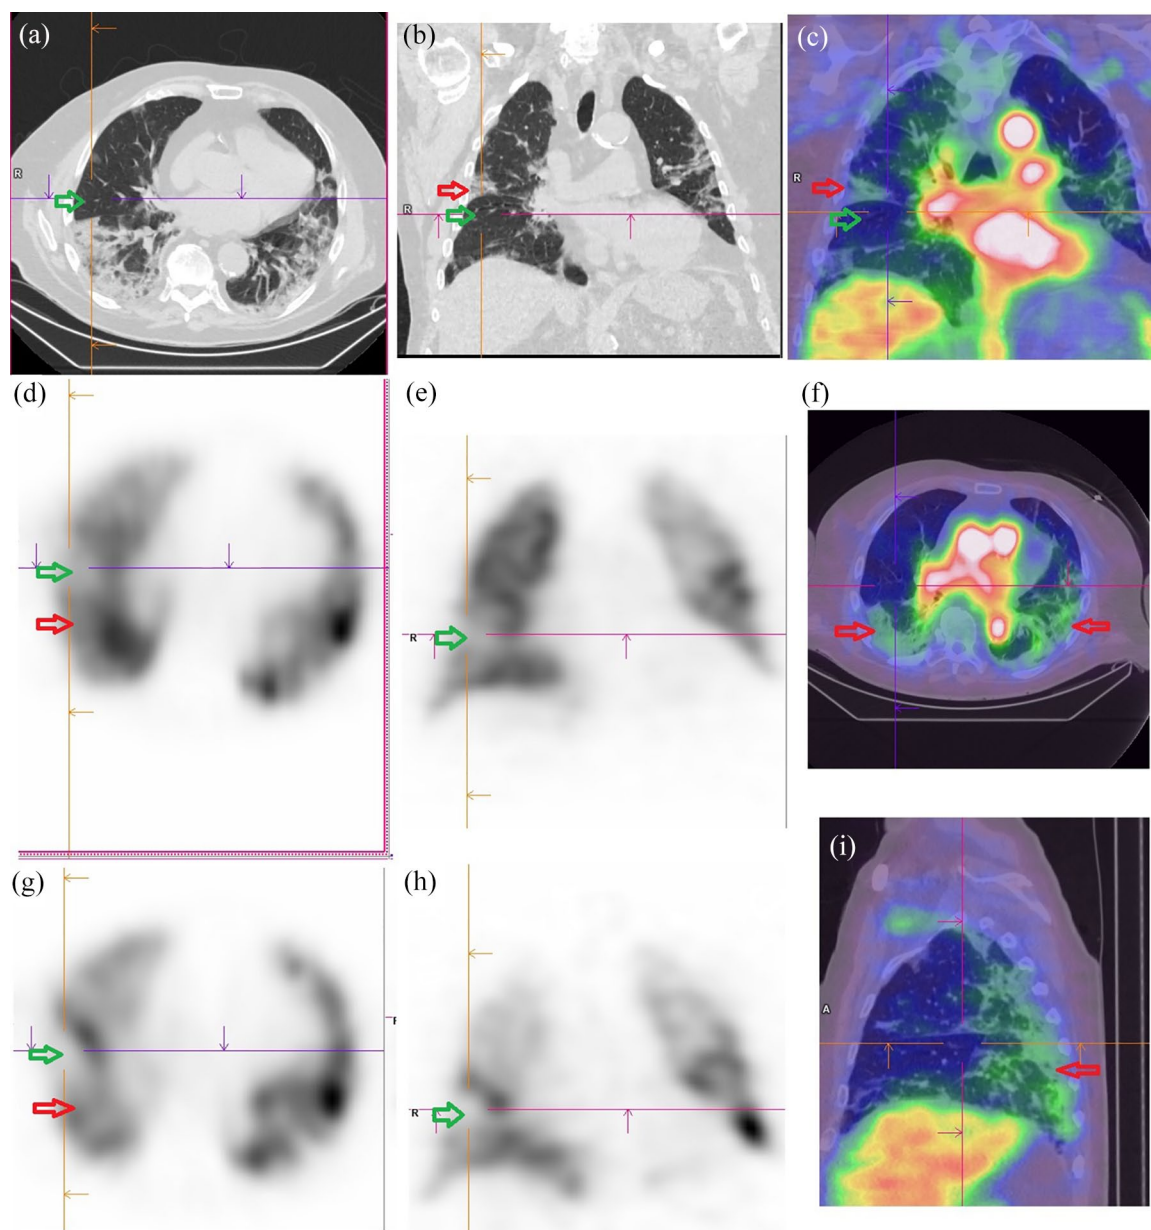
Patient no. 7. Axial (a) and coronal CT slices (b). Corresponding perfusion (d, e) and ventilation (g, h) scans. Corresponding coronal (c), axial (f), and sagittal (i) fused albumin and CT scans. Green arrow: non-COVID-19-involved segment of the right inferior lobe, with paradoxically matched hypoperfusion and hypoventilation, while the COVID-19-involved area just behind (red arrow) is normally ventilated and perfused. (c), (f), (i): Red arrow: significant albumin uptake in several COVID-19-related condensed areas.
